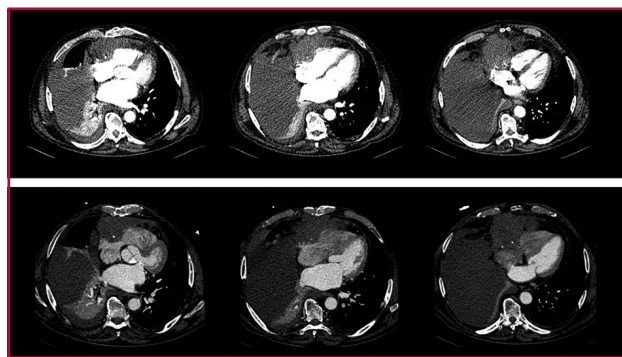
CT scan. *Top:* Unsynchronized CT scan, with a hypodense lesion over the right cardiac chambers and severe right pleural effusion with associated collapse. *Bottom:* Synchronized CT scan, with a right precardiac mass of 8.5 x 10 cm, enhanced after contrast injection. The tumor exerts mass effect and possibly infiltrates the right atrium, in contact with anterior chest wall and possible infiltration of the right ventricle.
